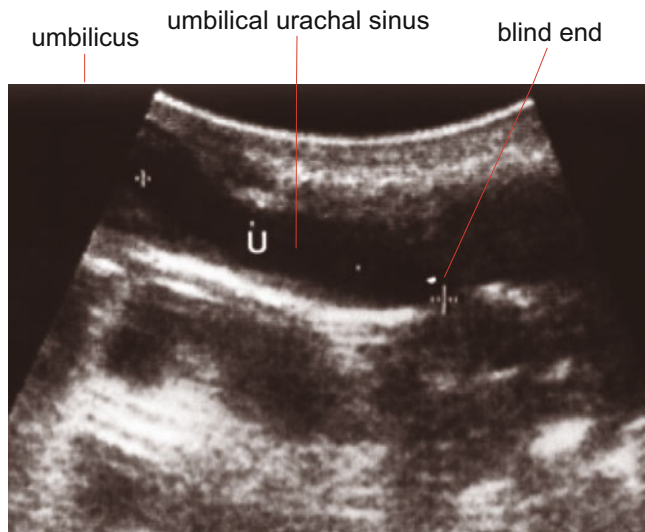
Umbilical urachal sinus: ultrasonography. Demonstration of the extraperitoneal blind-ending hypoechoic structure from the umbilicus
